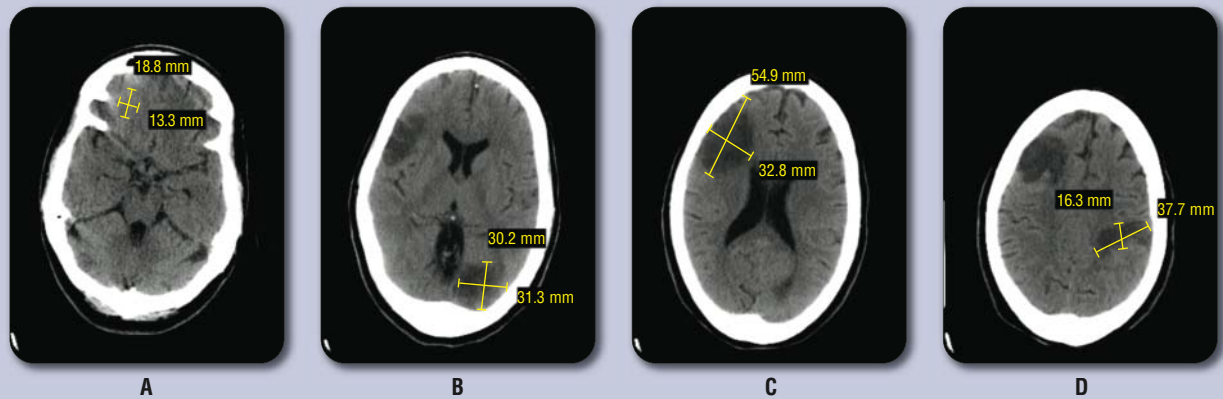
Figure Patient X's initial computed tomography scan without contrast material shows multiple infarcts in (A) right frontal lobe, (B) left occipital lobe, (C) right anteroparietal lobe, and (D) high left parietal lobe. Images are progressing (left to right) from the skull base toward the peak of the cranium.
